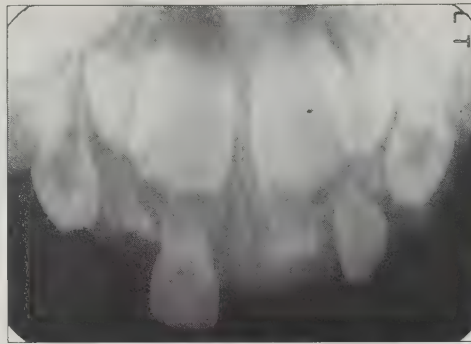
Maxillary anterior occlusal radiograph.
